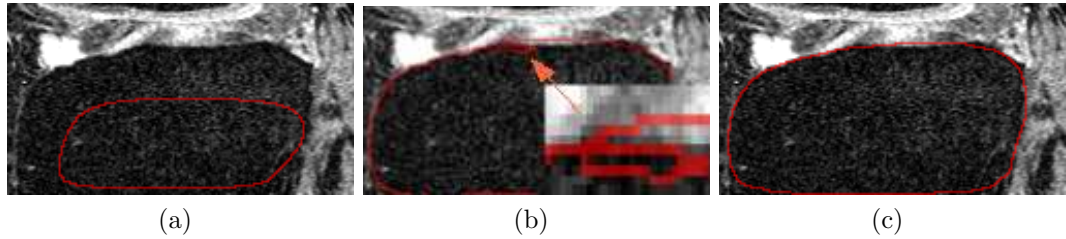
Tibia bone-cartilage interface segmentation in 3D performed using iterative graph searching. (a) An initial 3D contour (red line) placed on the 3D MR image of human tibia. (b) Iterative volumetric graph searching result (red line) performed along normal directions, notice the surface wrapping near the tibial cartilage that is detrimental to consequent cartilage segmentation. (c) Iterative volumetric graph searching result (red line) performed along ELF directions, no surface wrapping present – using the same initialization and the same number of iterations.
